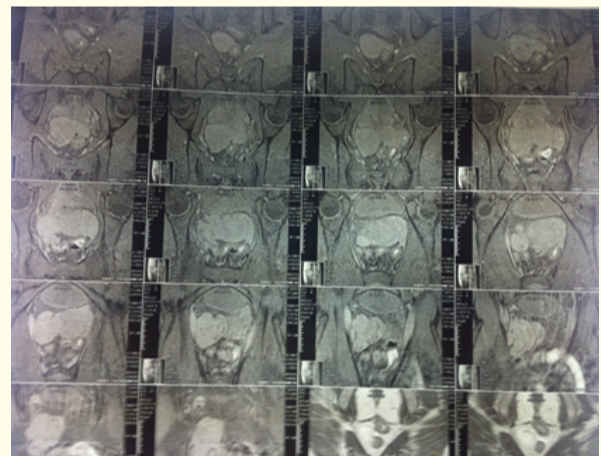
MRI T1 weight images showing a hyper vascular well defined hypo echoic solid mass - isosignal intensity with contrast enhancement, ovarian malignant mass was suspected.
